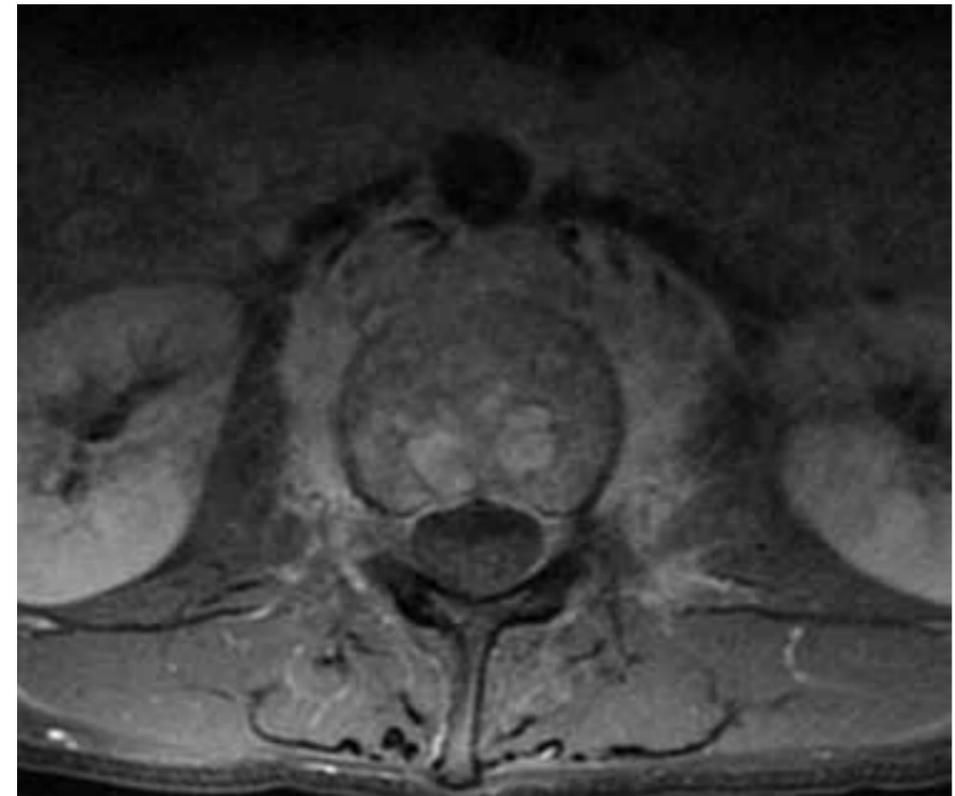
Image from the lumbar spine MRI showing Axial T1W with contrast at the L3 level.
